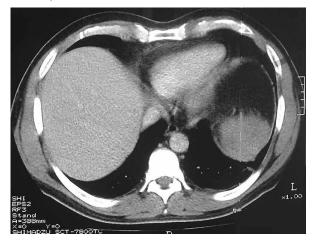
Initially computed tomography (CT) of the abdomen.
